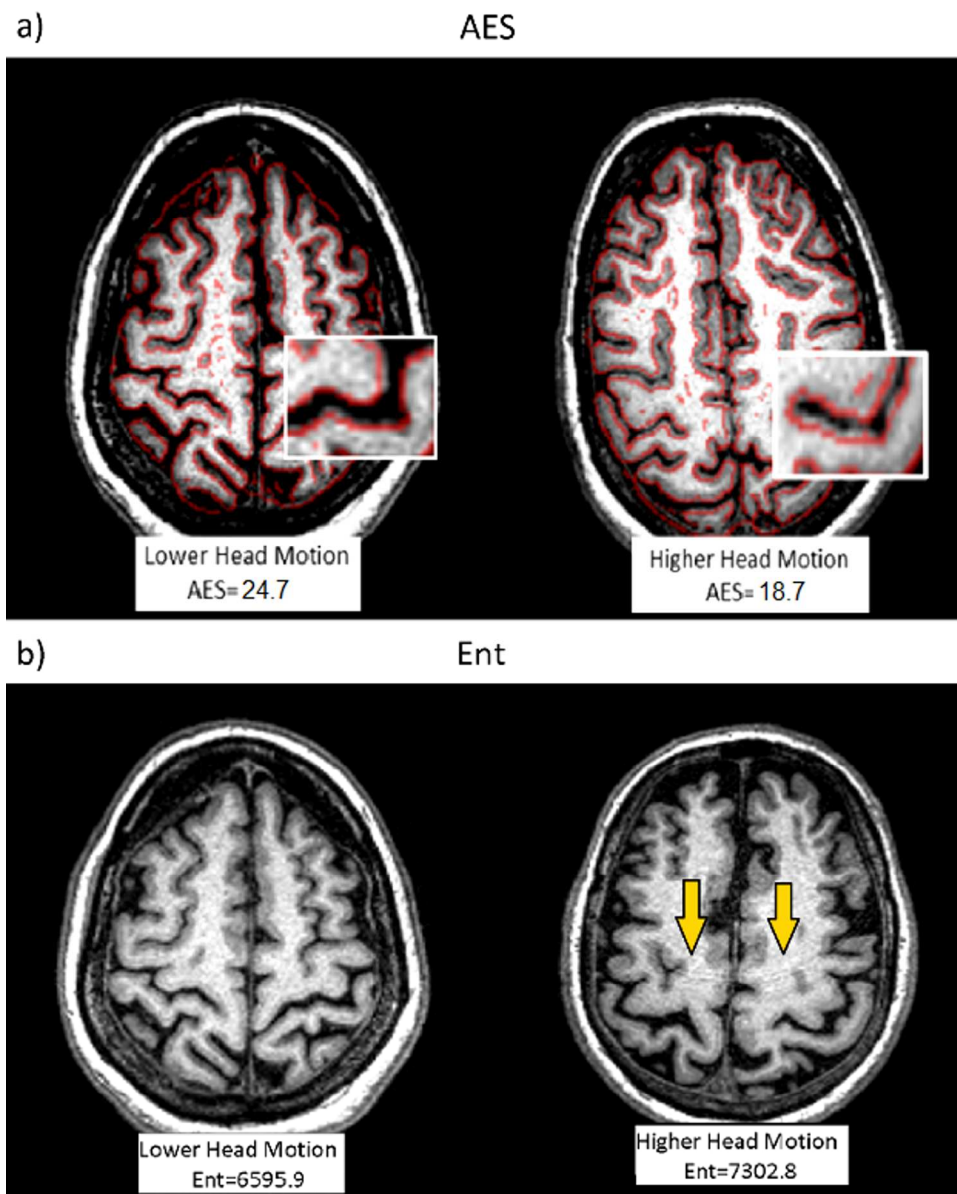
Head motion artifact examples in healthy controls (HC) and Parkinson's disease (PD) subjects with the corresponding quantitative characterization given by the average edge strength (AES, upper panel) and image entropy (ENT, lower panel) metrics derived from the corresponding structural T1-weighted images. Figure 1a (upper panel) shows an example where the head motion differences are quantitatively dominated by lower AES (32% lower due to higher image blurring) in the PD (right) relative to the HC (left), while both images have comparable ENT values across the two examples (5% difference). Figure 1b (lower panel) shows the converse, an example where head motion quantitative differences are dominated by higher ENT (11% higher due to more ringing artifacts) in the PD (right) relative to the HC (left), while AES was comparable across the two examples (3% difference).
